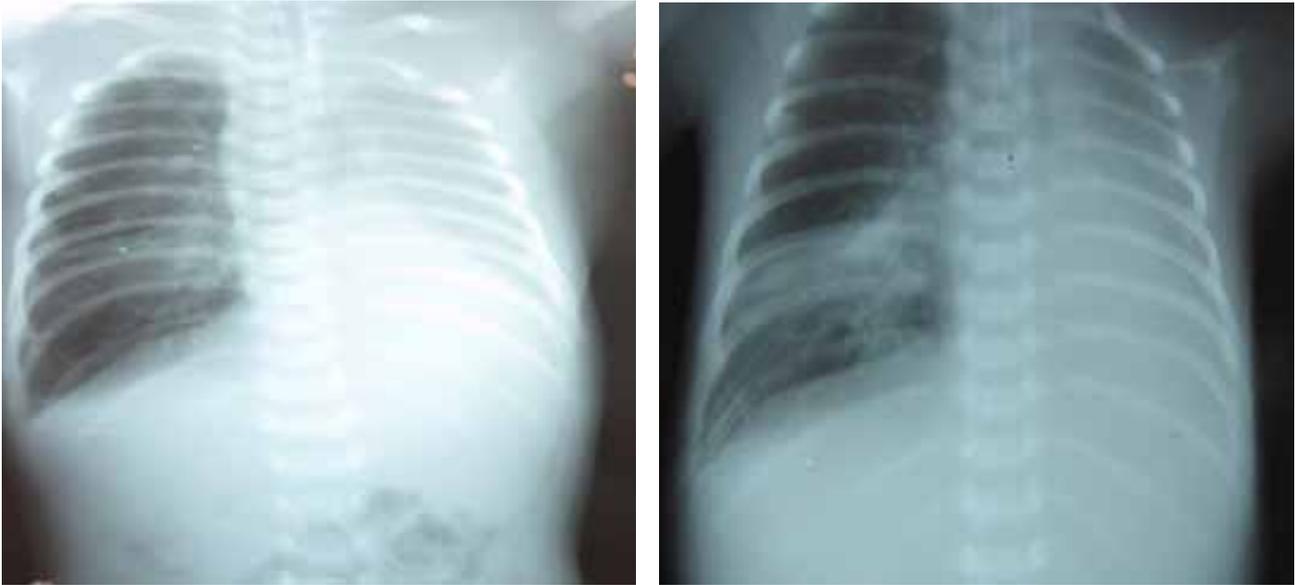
2 X-ray of the chest. Hyperneumatization of the right lung. The left lung field is reduced in size, pneumatization is visible only in the area of the upper lobe. Mediastinal structures are shifted to the left. High position of the diaphragmatic arch. Pneumonia of the lower lobe of the right lung.
